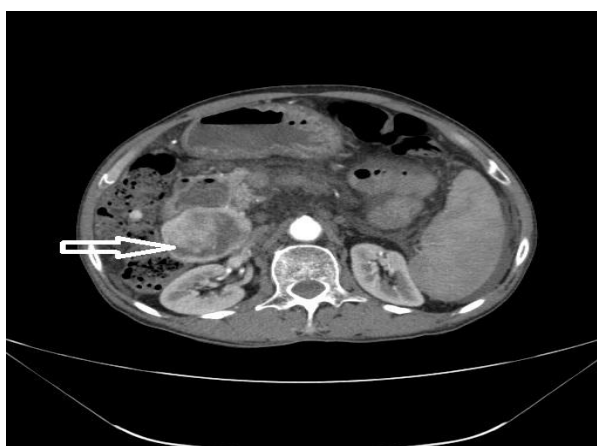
Axial arterial phase contrast enhanced CT image showing Large heterogeneously enhancing lesion in 2nd part of duodenum suggesting malignant transformation of a polyp.
